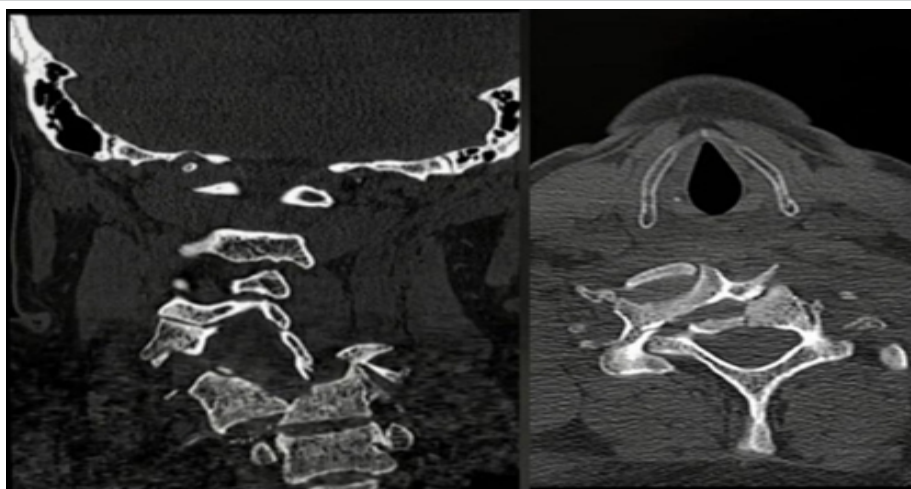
Pre-operative computed tomography (CT) cervical spine – coronal and axial views. Coronal (left) and axial (right) CT images demonstrating bilateral facet dislocation at C6–C7, burst fracture of C7 with posterior element comminution, and fractures extending into the transverse foramen bilaterally. Findings are consistent with arbeitsgemeinschaft für osteosynthesefragen Spine Type C/F4 injury.
